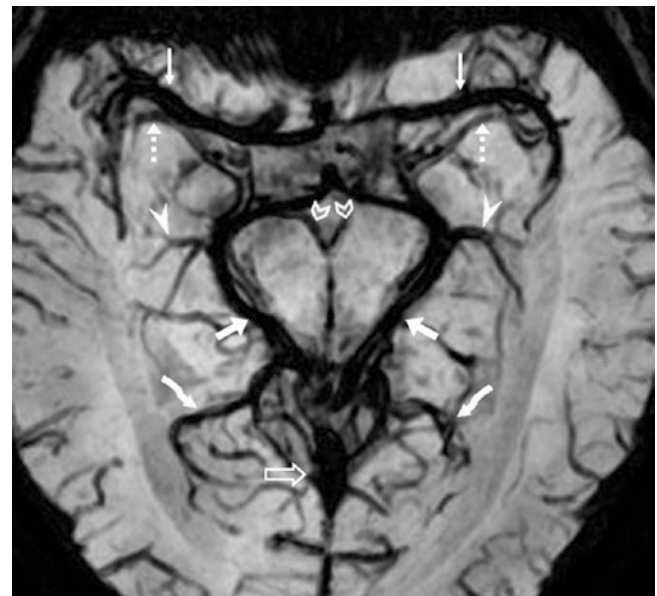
A 3 T MRI with 12 mm thickness SWI in a 13-year-old shows relative symmetry of the BVRs (*short arrows*) and deep MCVs (*dotted arrows*), but there is asymmetry of the IOVs (*curved arrows*) and IVVs (*arrowheads*). Note normal interpeduncular veins (*chevrons*). The MCAs (*thin arrows*) are dark because of technique (selected TE and flip angle)
